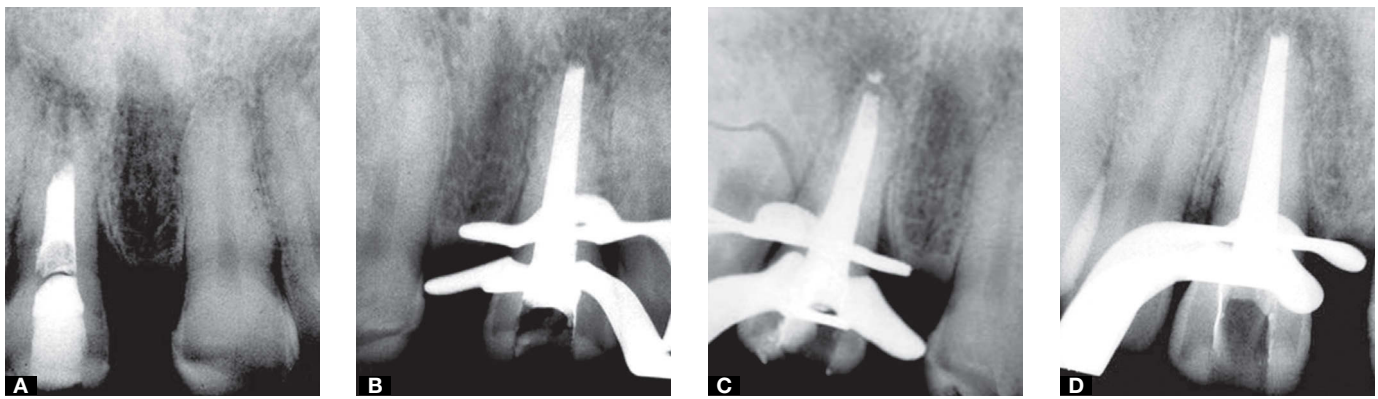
Periapical radiographs of the upper right central incisor. A) Diagnostic radiographic exam. Note the radiopaque intracanal dressing partially filling the root canal and the provisional restoration with radiopaque material and incomplete root formation. B) Radiographic exam performed in the second appointment, in the end of the treatment, consisting of biomechanical preparation and intracanal dressing with calcium hydroxide paste and iodoform. C) Radiographic exam at the third appointment, in the end of the treatment, consisting of careful biomechanical preparation and change of intracanal dressing with calcium hydroxide paste and iodoform. D) Radiographic exam at the fourth appointment, in the end of the treatment, consisting of careful biomechanical preparation and change of intracanal dressing with calcium hydroxide paste and iodoform.
